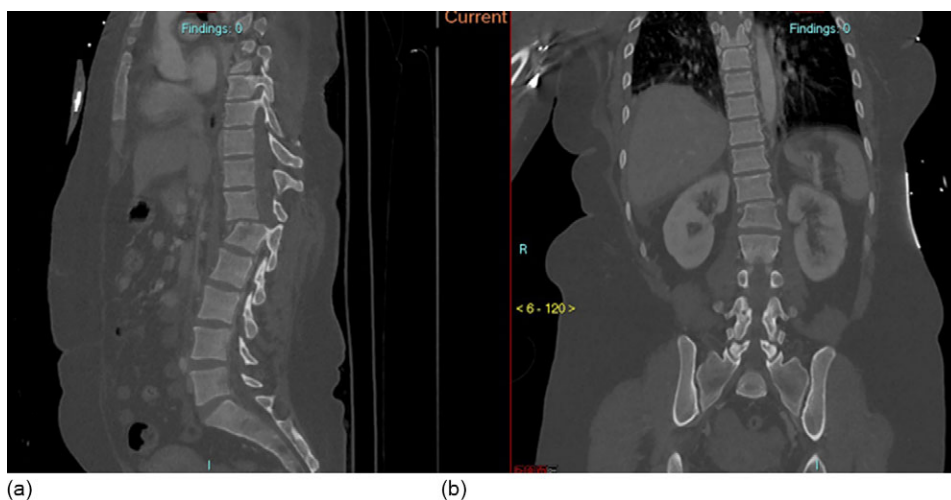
Sagittal and coronal CT reconstructions
